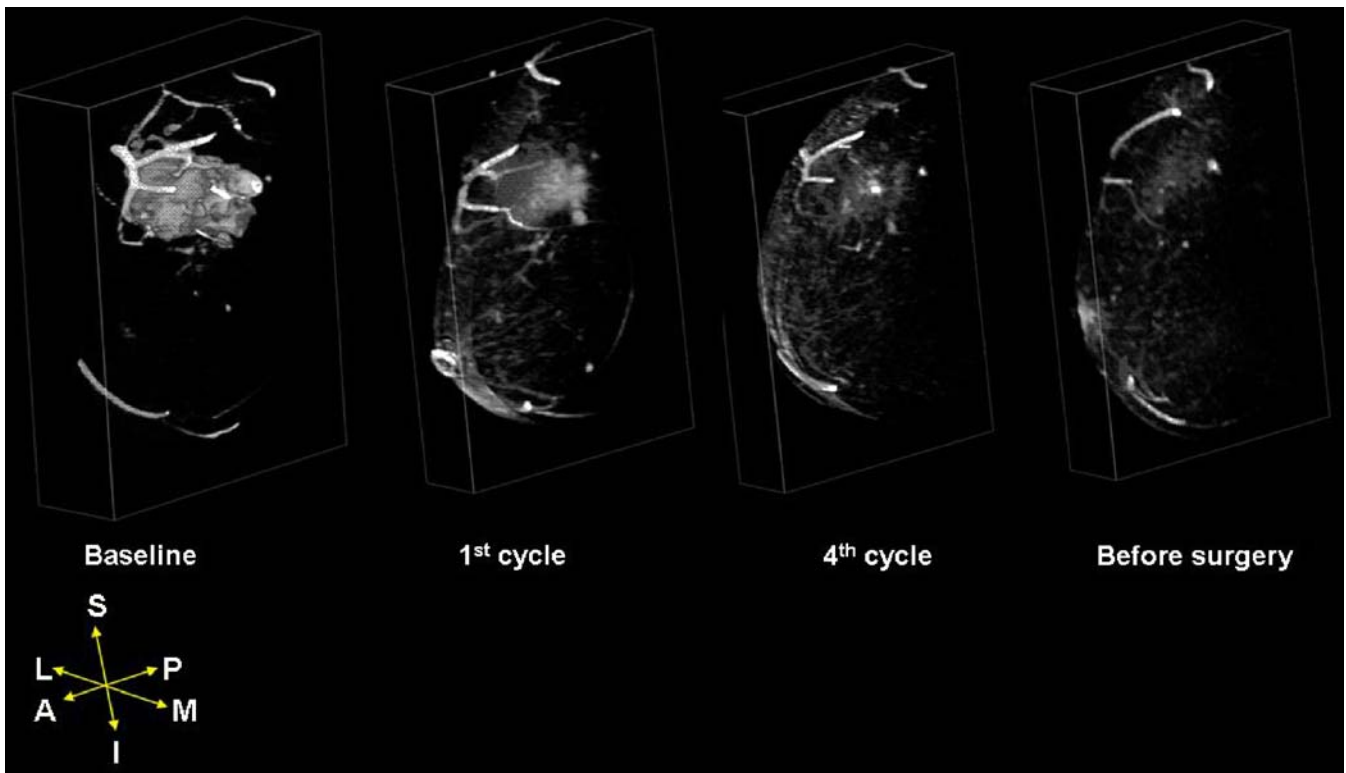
Representative 3D visualization of dynamic contrast-enhanced MR images after therapeutic intervention in a 54 y/o female with T3N0M0 invasive ductal carcinoma of a large operable breast lesion. There was a steady reduction in tumor volume from baseline until surgery.
